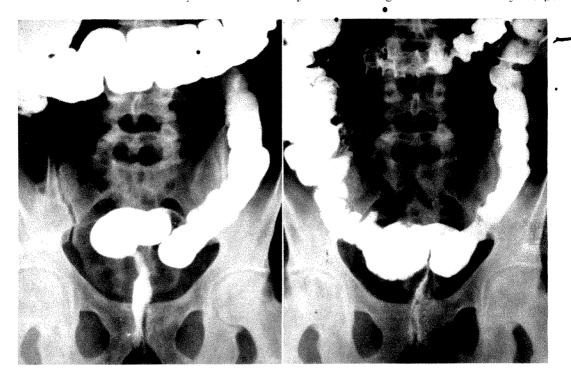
Lymphogranuloma venereum affecting a white man, thirty-five years old; Frei test positive; proctoscopic diagnosis was lymphogranuloma venereum; *left*, roentgenogram of colon distended with opaque enema; *right*, after evacuation of opaque enema.
